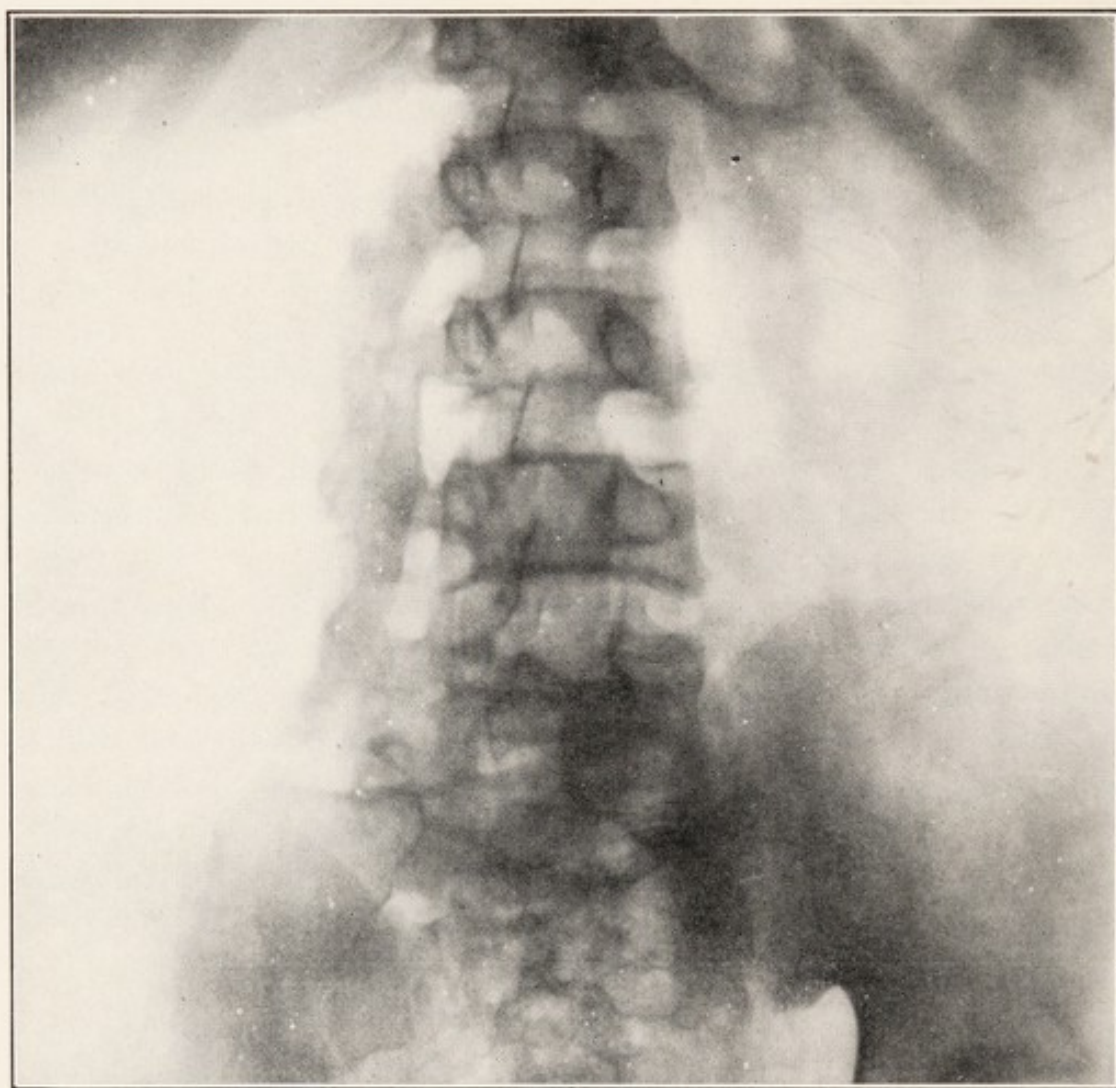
X-RAY SHOWING MYOSITIS OSSIFICANS IN LUMBAR MUSCLES FOLLOWING CONTUSIONS.
